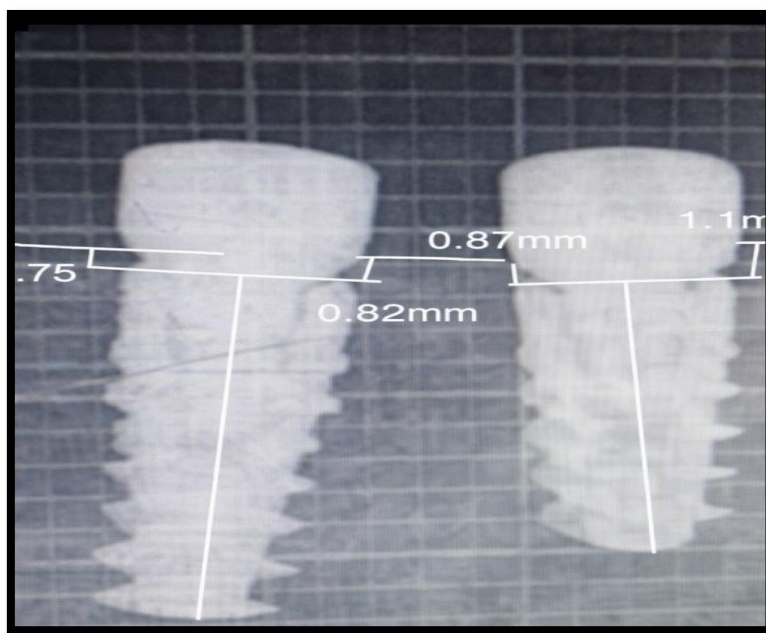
Radiographic assessment of crestal bone level using intraoral periapical radiograph analyzed with ImageJ software.
